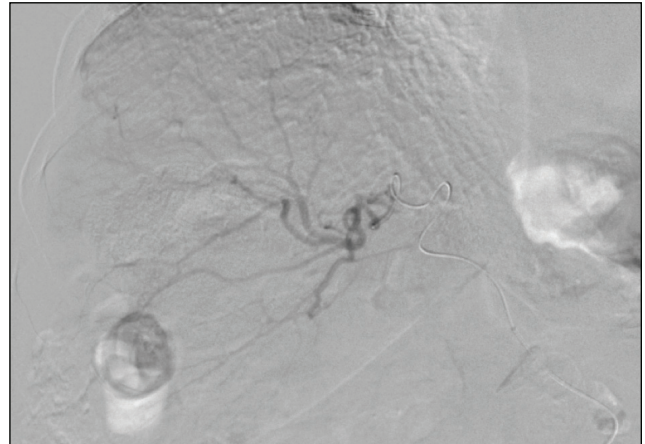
Angiogram showing the SeQure® microcatheter through the tortuous right hepatic artery branches in a distal branch, which was shown to supply both HCCs on rotational CT.
